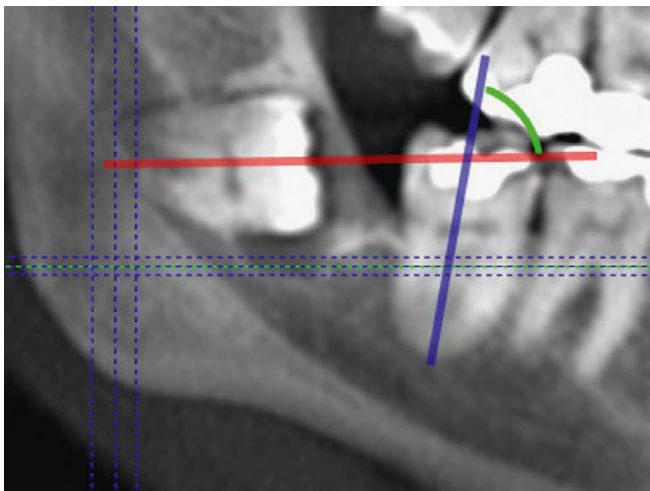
Measuring the sagittal angulation: angle (green), between the tooth axes of the third molar (red line) and the second molar (blue line) on the reconstructed orthopantomogram.
